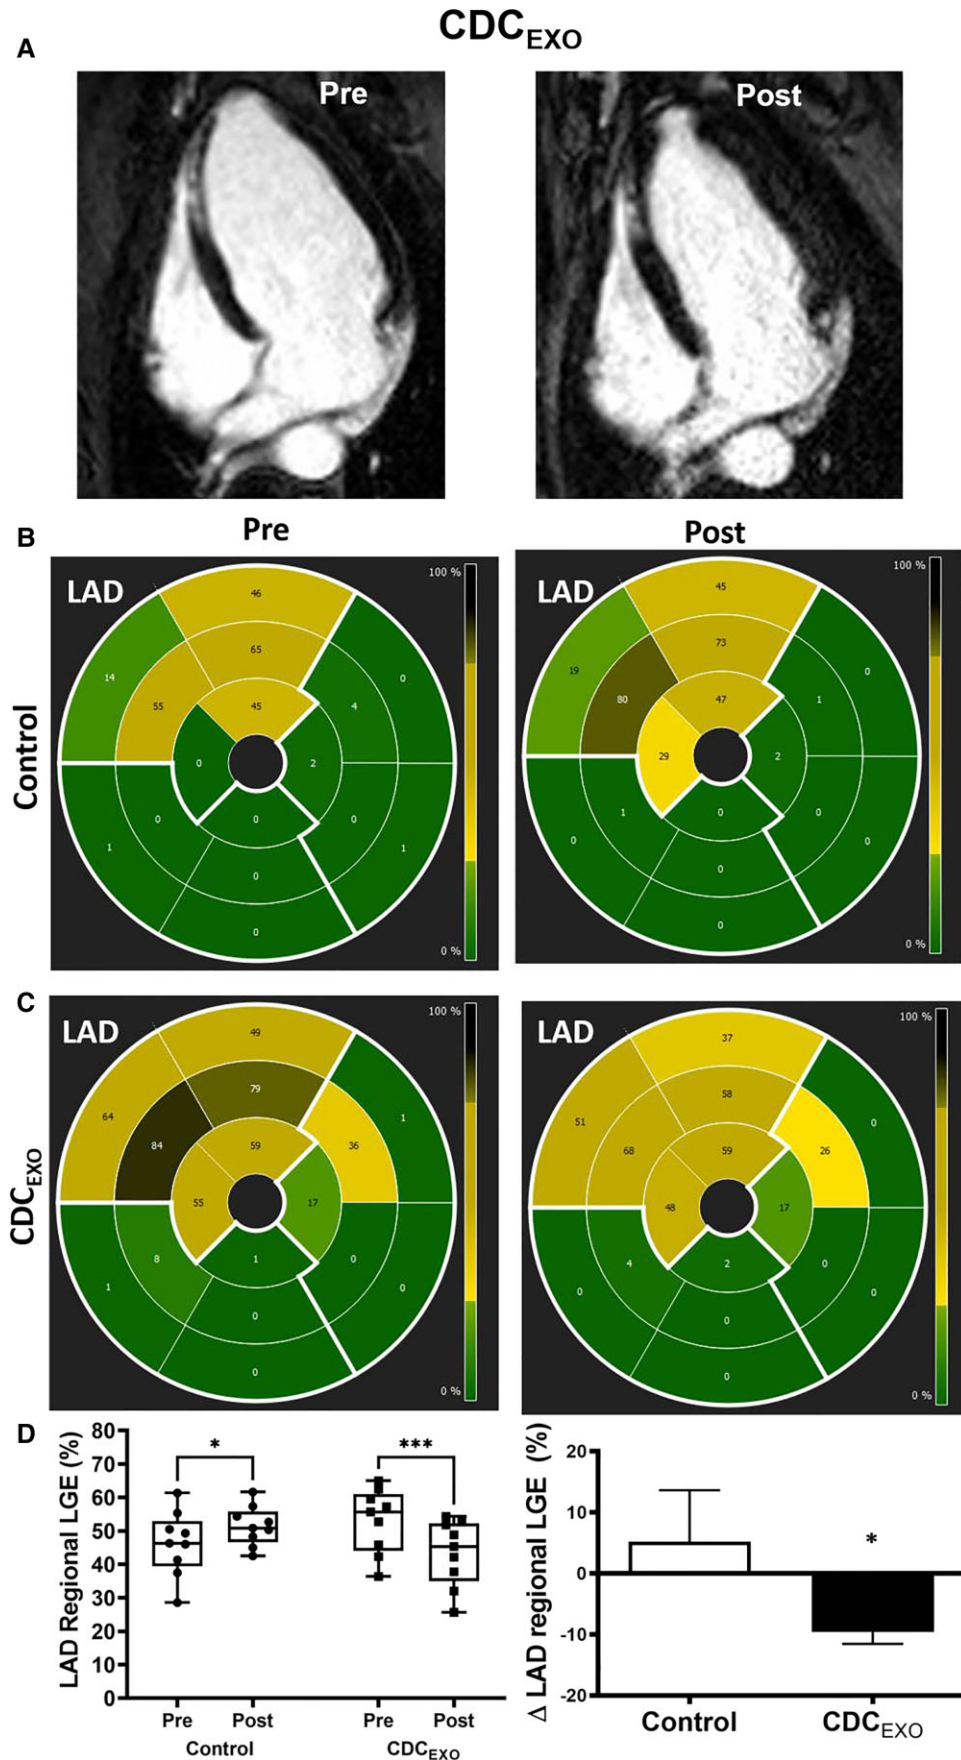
Myocardial scar by magnetic resonance imaging. (A) Representative four-chamber magnetic resonance image of infarcted ventricular myocardium identified by late gadolinium enhancement. Left is a baseline image pre-injection of CDC_{EXO} with follow-up examination 2 weeks
